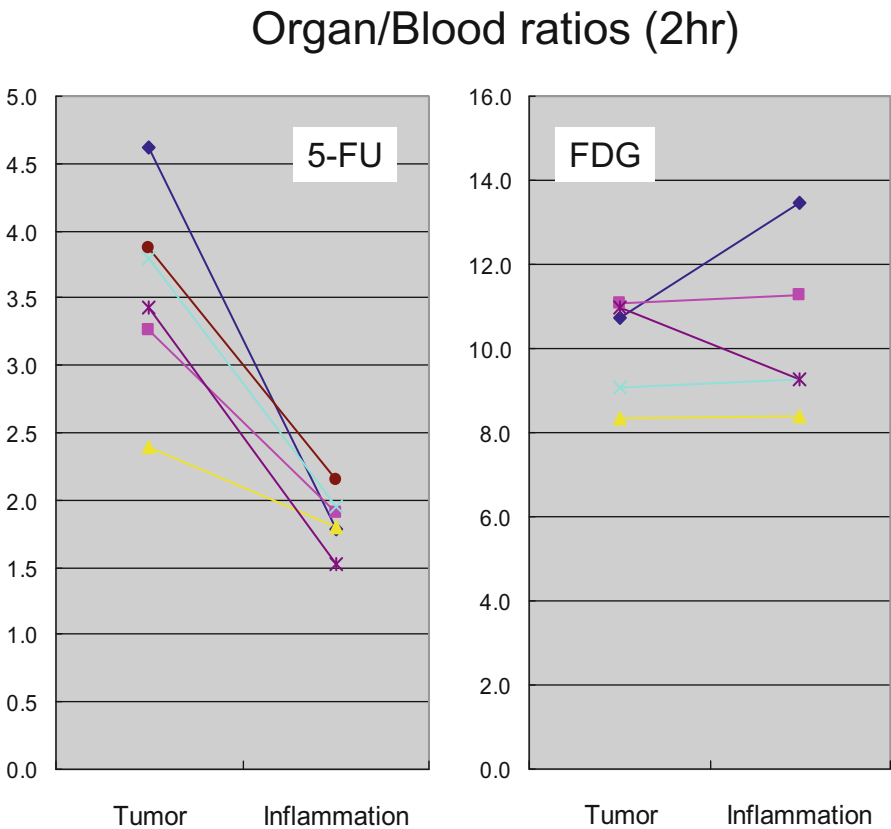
The difference between tumor and inflammation uptake of ^{18}F -5-FU. *FDG*, fluorodeoxyglucose
